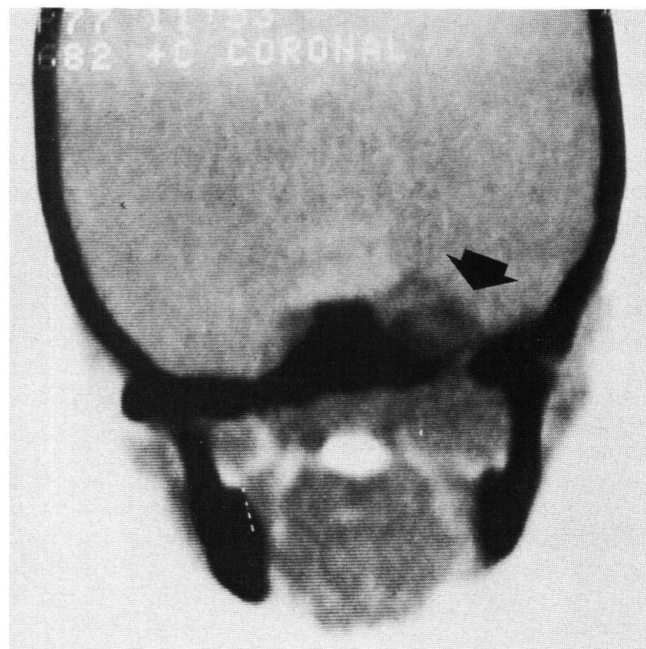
Coronal CT Scan showing an enhancing lesion which has penetrated through the base of the skull into the intracranial extradural compartment.
